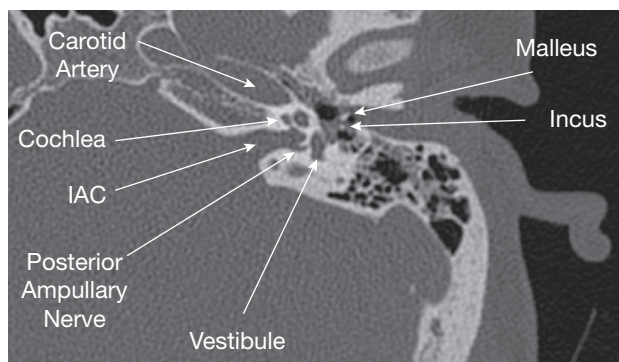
The axial CT of our patient's temporal bone demonstrates the posterior ampullary nerve. "IAC" stands for "internal auditory canal."
